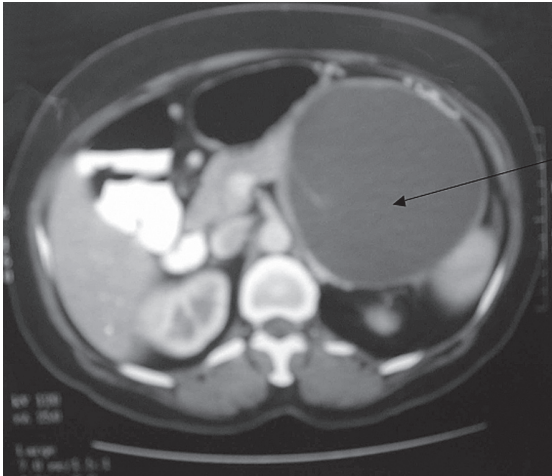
Axial CT image shows a large cystic lesion in the tail of the pancreas.
